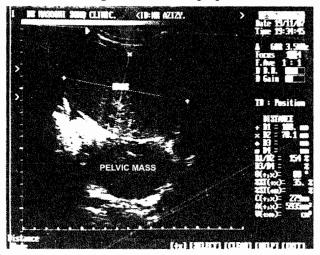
Pelvic masses and a lesion at the behind of bladder were reported in pelvic ultrasonography.
